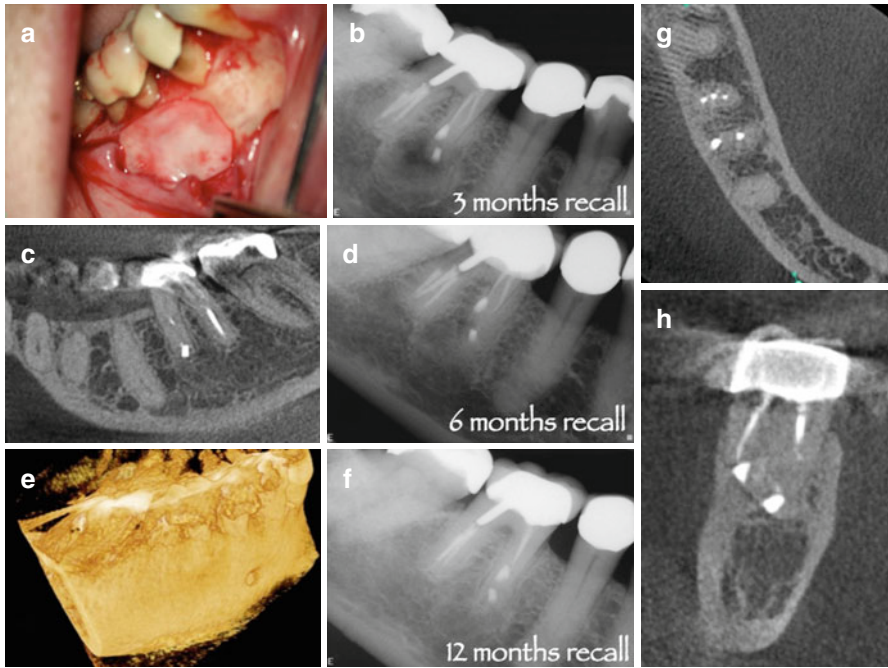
Continuation of case presented in Fig. 6.13: clinical picture of CopiOs™ membrane without graft material (a). Periapical radiograph of 3-month recall (b). CBCT sagittal view, periapical radiograph, and 3D rendering at 6-month recall (c–e). Periapical radiograph, axial and coronal views of tooth #30 at 12-month recall demonstrating complete remodeling of the defect including the buccal cortical plate (f–h)
